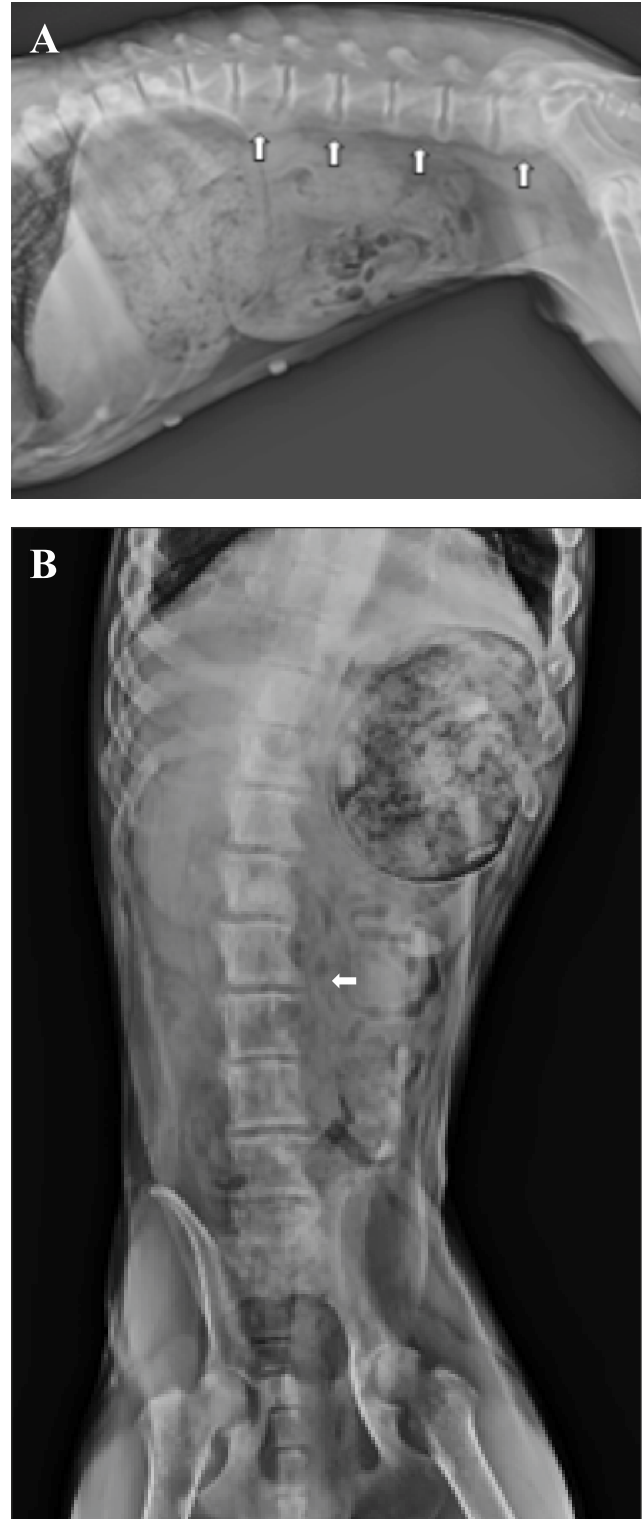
Lateral (A) and ventro-dorsal (B) radiographs of Case-8 demonstrating (arrows) the newly formed bone DISH present along the ventral aspect of lumbar vertebrae(L1-L7) and (L7- Sacrum). Due to stiffness and back pain left vertebral curvature was also seen.
